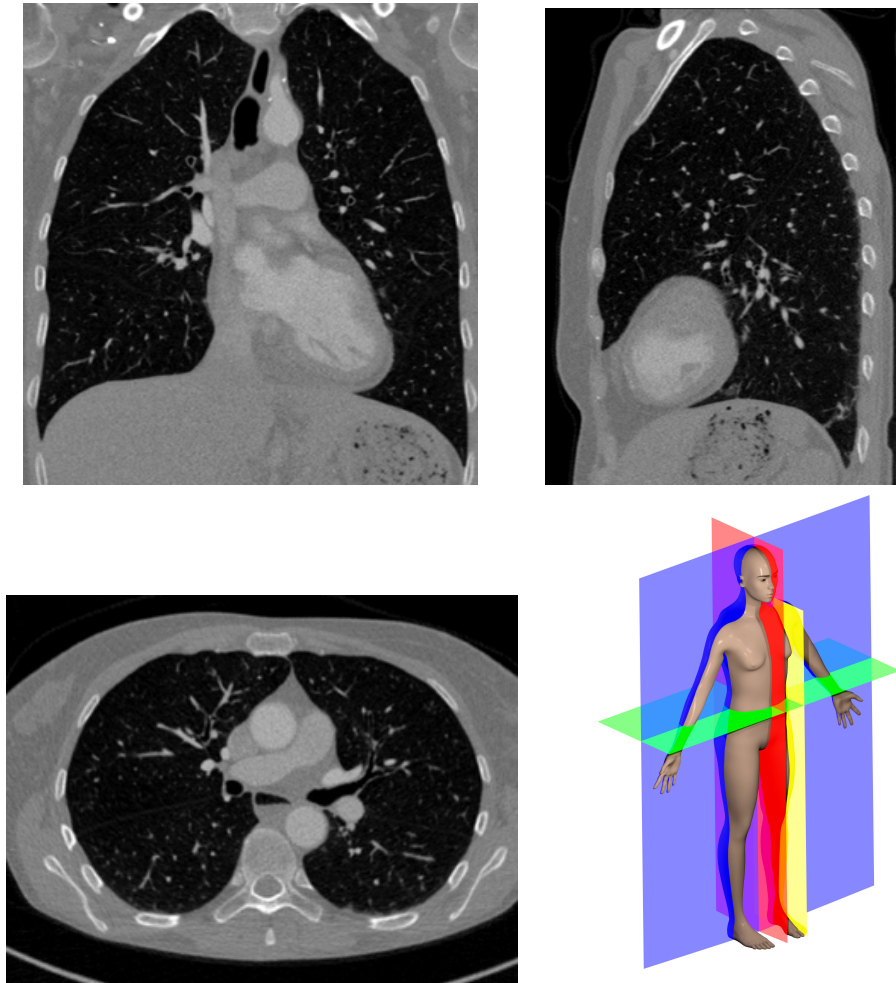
Slices of a CT image; top left: coronal slice; top right: sagittal slice; bottom left: transverse slice; bottom right: planes of the human body [51]; red: sagittal plane; yellow: parasagittal plane; blue: coronal plane; green: transverse plane
